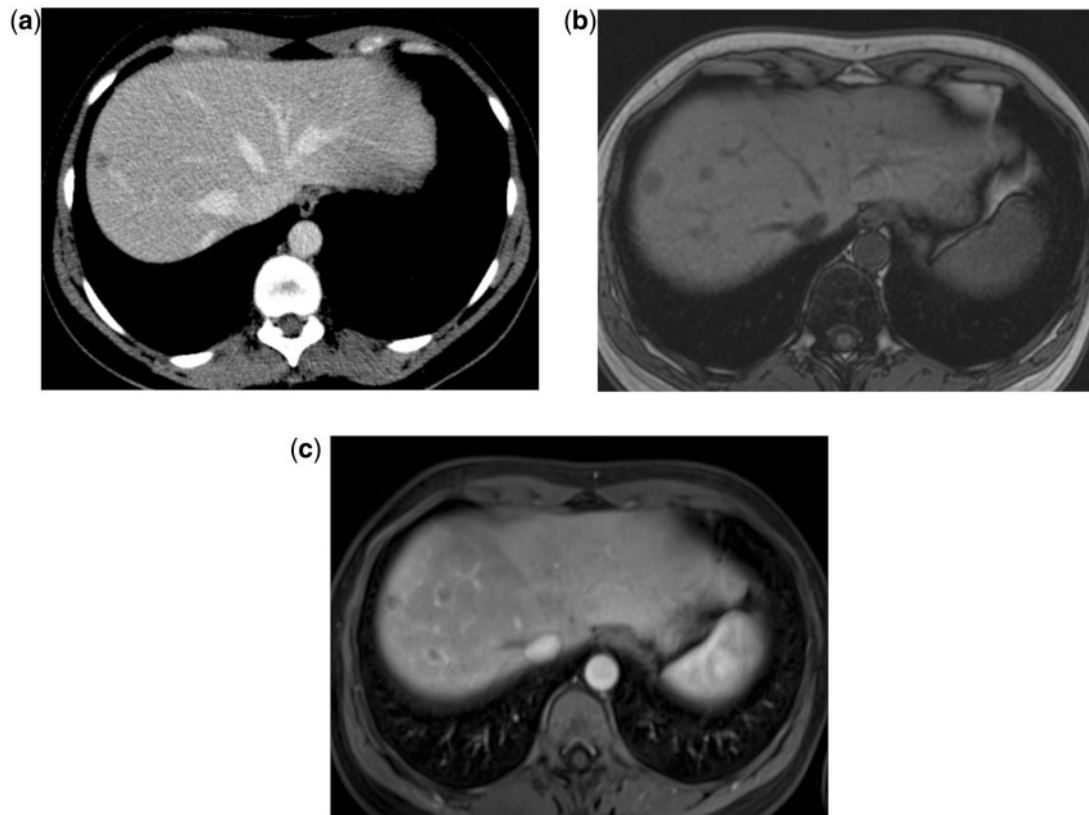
Preoperative assessment of colorectal liver metastases. At the contrast-enhanced MDCT, one small lesion is faintly seen in the right lobe. Unenhanced T1-weighted GRE (b) and gadolinium-enhanced MR images in the venous phase (c) reveal 3 lesions in the right lobe with rim enhancement, suggestive of metastases.
